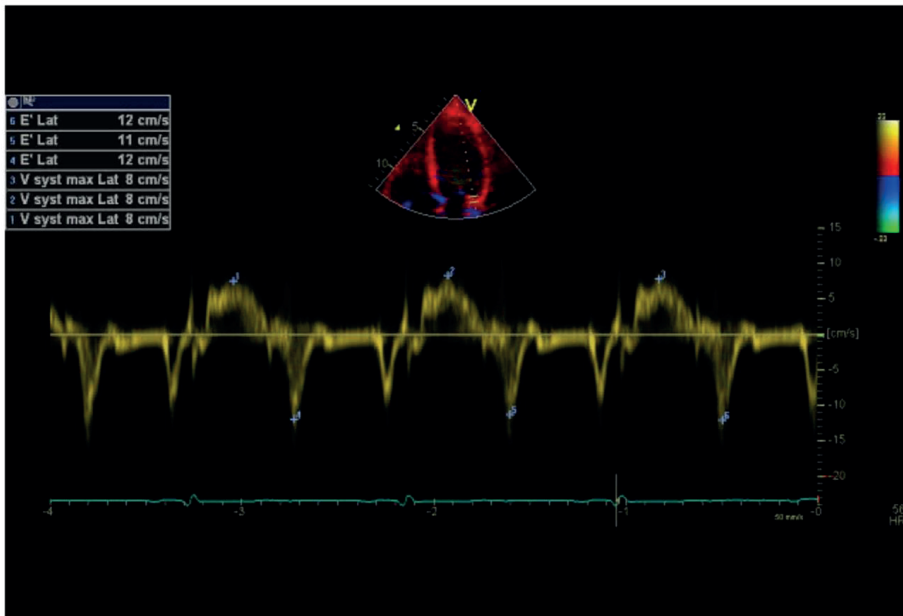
Pulsed tissue Doppler recordings on the lateral mitral annulus.
